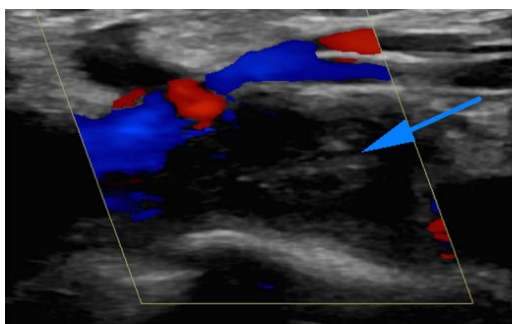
Doppler ultrasound scan. Blue arrow: occlusive thrombus in the left subclavian vein.
